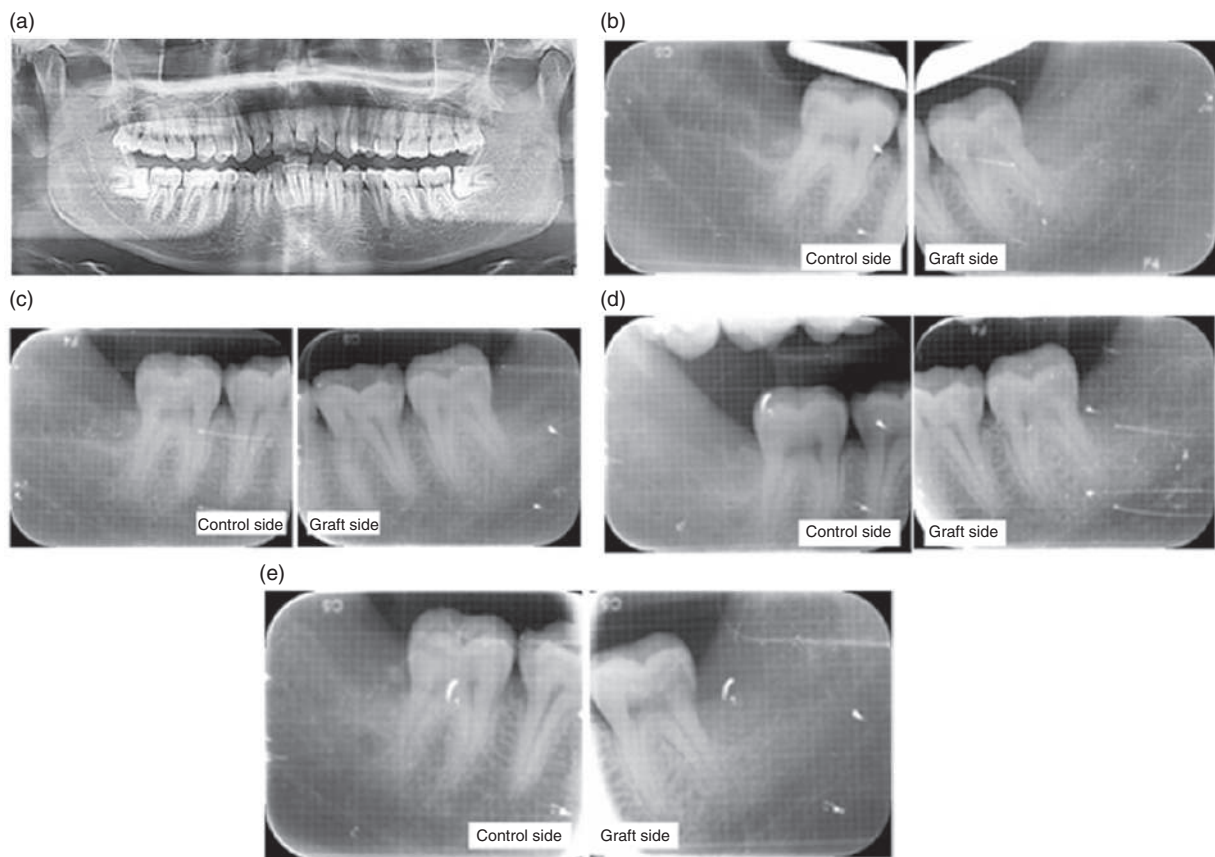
(a) Preoperative orthopantomograph showing similar impacted bilateral mandibular teeth. (b) IOPAR of control and grafted side immediately after grafting at baseline. (c) IOPAR of control and grafted side at first month after grafting. (d) IOPAR of control and grafted side at third month after grafting. (e) IOPAR of control and grafted side at six months after grafting.
